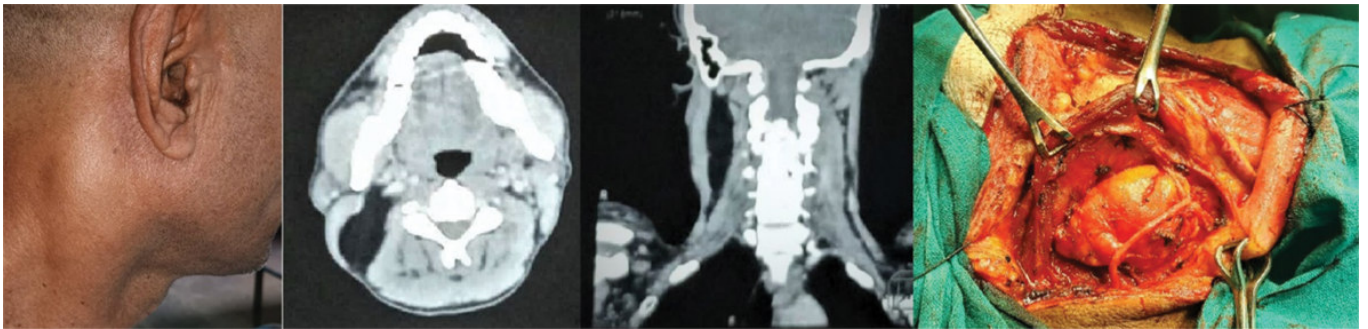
(left to right) 5a. Clinical Picture of the patient; 5b, 5c. CE- CT of the lesion in axial and coronal view; 5d. Intra operative picture showing the lesion after dissection.
